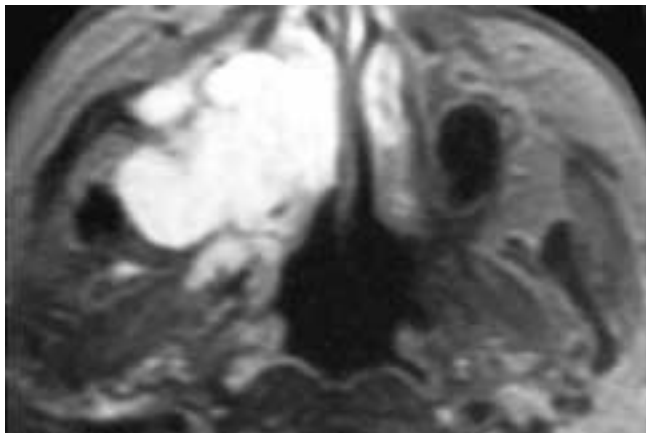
Axial T2-weighted MR image shows an expansile right maxillary sinus mass that extends into the infratemporal fossa. The tumor has high signal intensity, suggesting that it contains water-like products such as mucoid secretions. This patient had a mucoepidermoid carcinoma.
